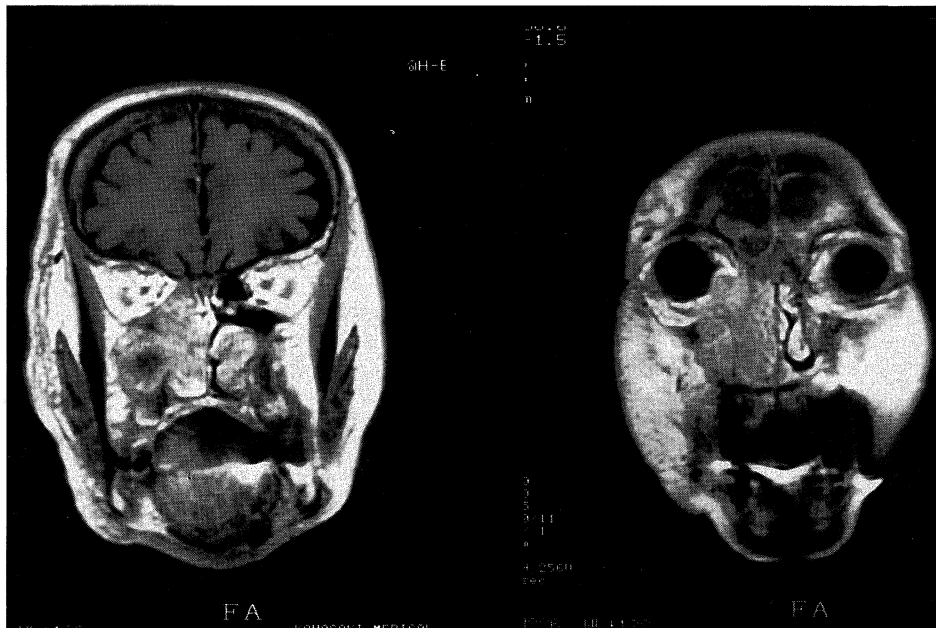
MRI (coronal view) showed that a tumor filled the right nasal cavity, maxillary sinus and ethmoid sinus, but no intracranial invasion was demonstrated.
